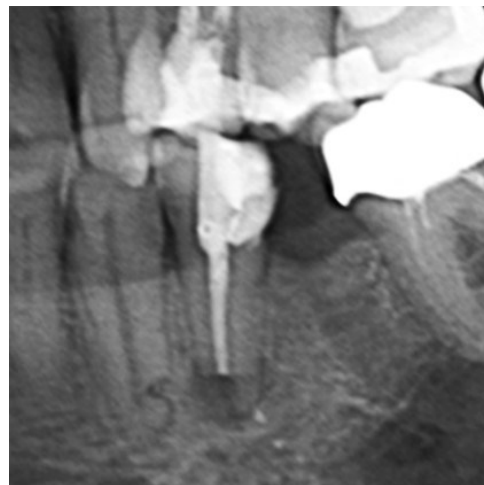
X-ray five years after damage: recovery of root 33
